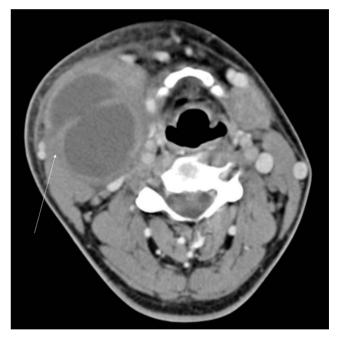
Axial contrast-enhanced CT showing a septated thick-walled right level 2 mass (white arrow) displacing the submandibular gland anteriorly and deep to sternomastoid in keeping with an infected second branchial cleft cyst.
